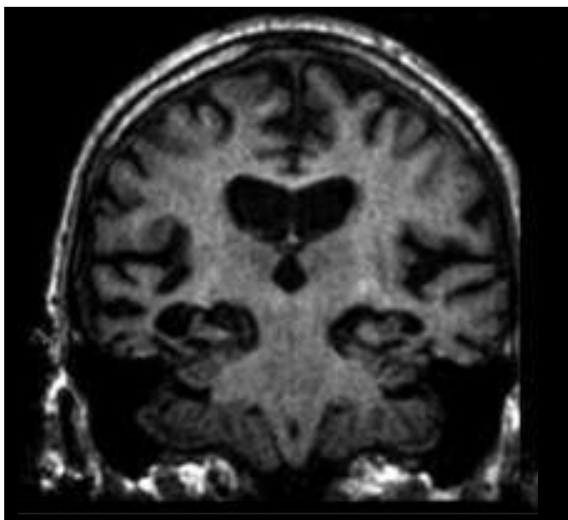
T1-weighted MRI image showing AD typical atrophy: medial temporal and frontotemporal cortical. Coronal view.
